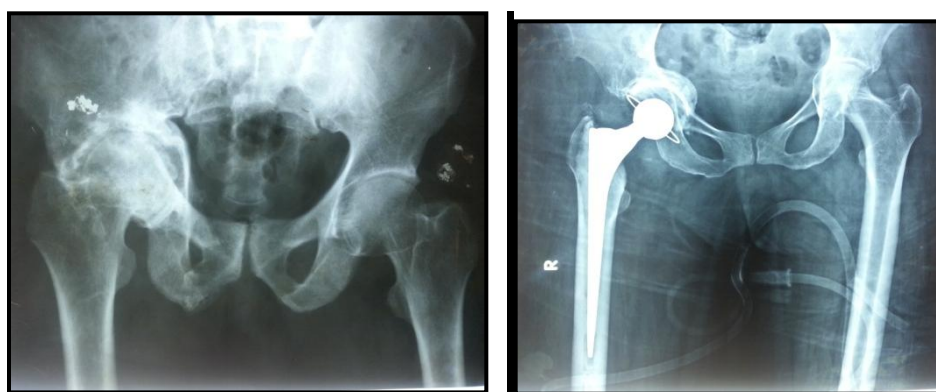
Plain x-ray of right hip of seventy years old lady with right protrusion acetabulum (A), after cemented total hip replacement (B).
